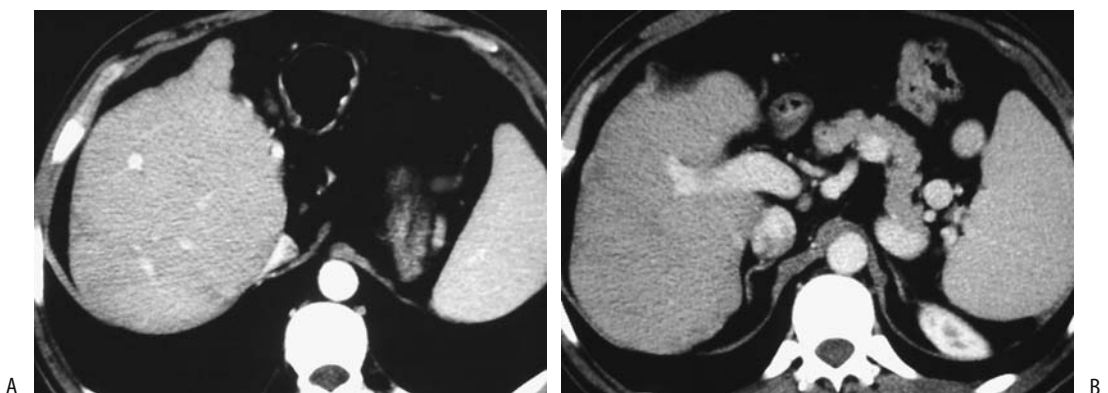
Left lobe atrophy. A,B: Views from contrast-enhanced CT reveal an atrophic left portal vein and absent left lobe. (Source: Gallego C, Velasco M, Marcuello P, Tejedor D, De Campo L, Frieria A. Congenital and acquired anomalies of the portal venous system. *RadioGraphics* 2002;22:141–159, with permission from the Radiological Society of North America.)
